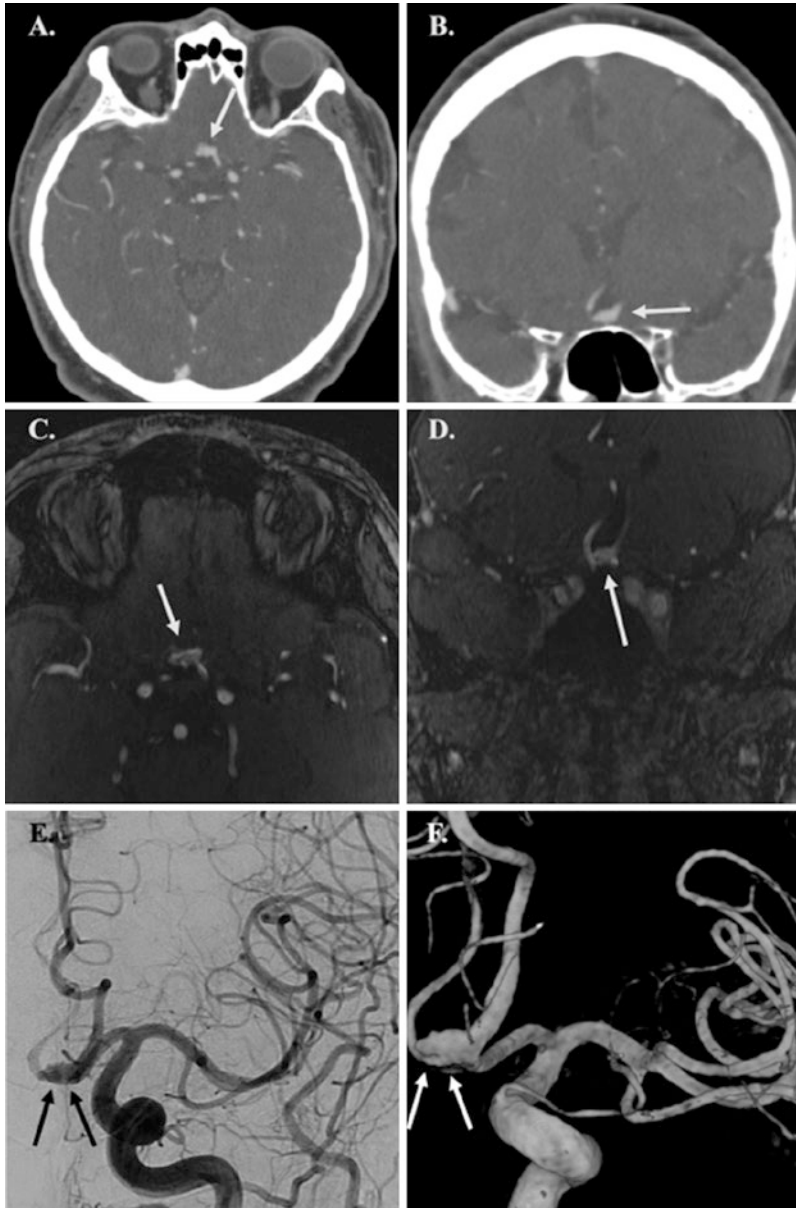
(a, b) Axial and coronal CTA MIP images demonstrating a saccular aneurysm of the anterior communicating artery (arrows). (c, d) Axial and coronal 3D-TOF-MRA images again demonstrating a saccular aneurysm of the anterior communicating artery (arrows). (e) Frontal DSA projection again demonstrating the anterior communicating artery aneurysm (arrows) visualized on CTA and MRA. (f) 3D rotational angiographic image provides better visualization of the aneurysm (arrows). On this image, a focal bleb arising from the right side of the aneurysm sac and a small perforator vessel arising directly from the aneurysm dome are more conspicuous than on 2D DSA alone
